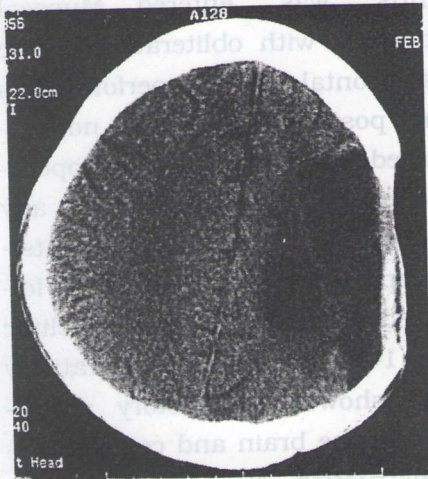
Preoperative brain CT.
